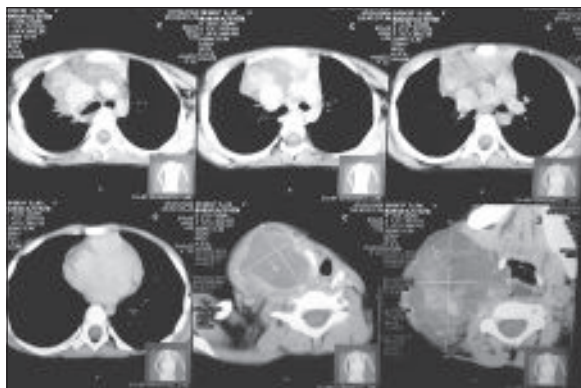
CT Scan of the Chest showing large anterior-superior mediastinal mass.
